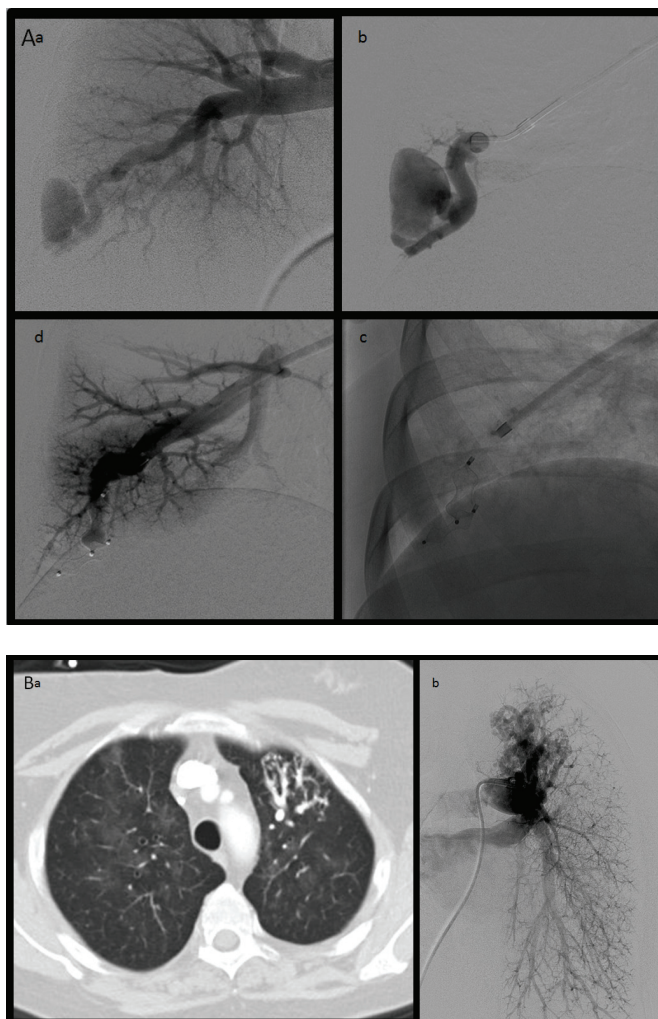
Pulmonary arteriovenous malformations (PAVMs). A) Pulmonary angiogram of a right basal PAVM with two dominant feeding vessels before (a,b) and after (c,d) embolisation with Amplatzer vascular plugs (AGA Medical Corporation, Plymouth, MN, USA). The patient was diagnosed by family screening, but had had a stroke previously. B) Computed tomography (a) and pulmonary angiogram (b) showing a diffuse PAVM in the anterior segment of the left upper lobe. The PAVM had been diagnosed following presentation with a cerebral abscess: post-embolisation, the arterial oxygen saturation increased from 89% supine, 91% erect to 93% supine, 95% erect with symptomatic improvement.
